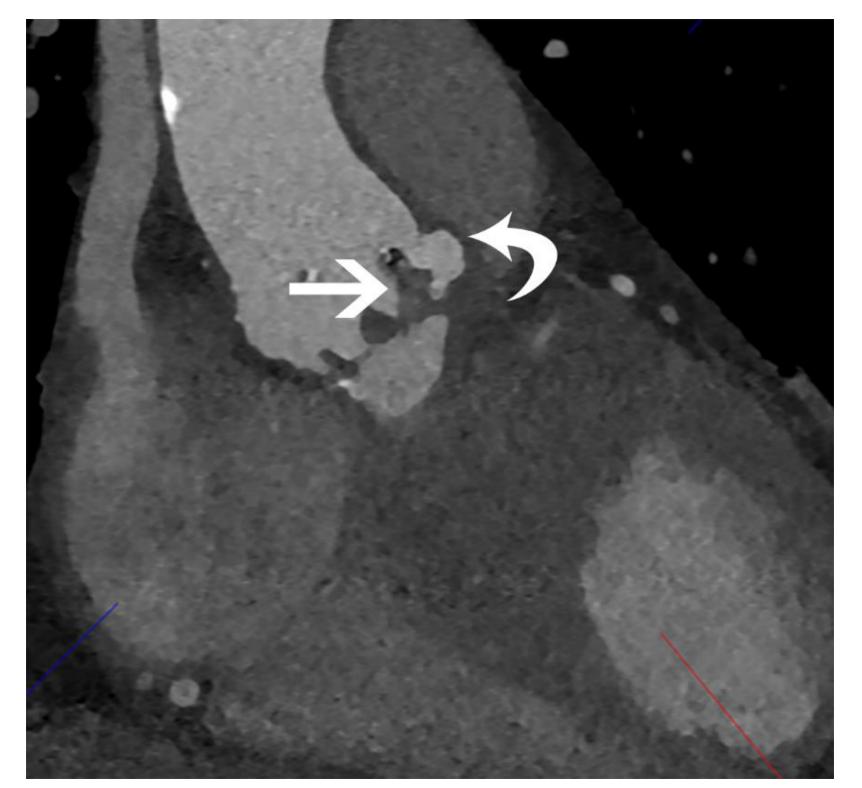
A. Coronal reconstructed CT image shows a vegetation attached to the aortic valve leaflet (straight arrow). There is also an infectious pseudoaneurysm adjacent to the valve (curved arrow)
